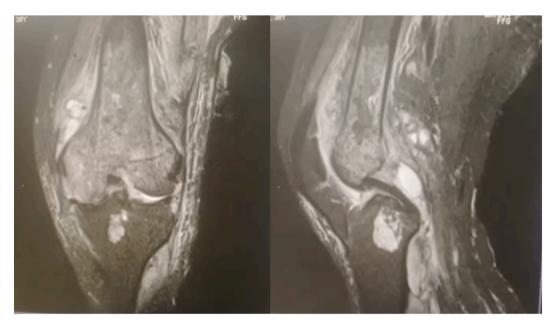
PD Fat Sat sequence of MRI knee showing intracavitory lesion involving the distal third of femur with surrounding bone oedema, periosteal reaction and surrounding significant soft tissue oedema.
